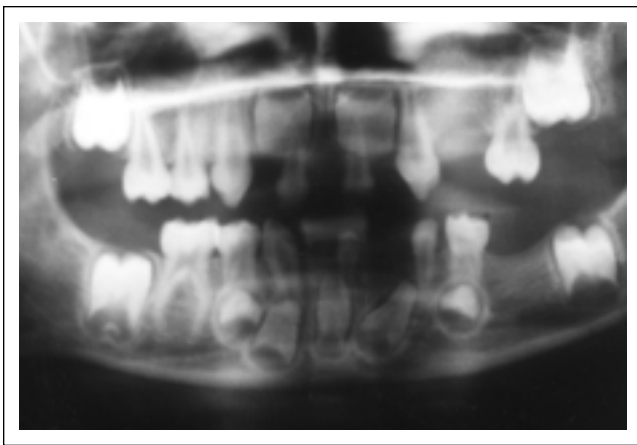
Panoramic radiograph showing absence teeth.
